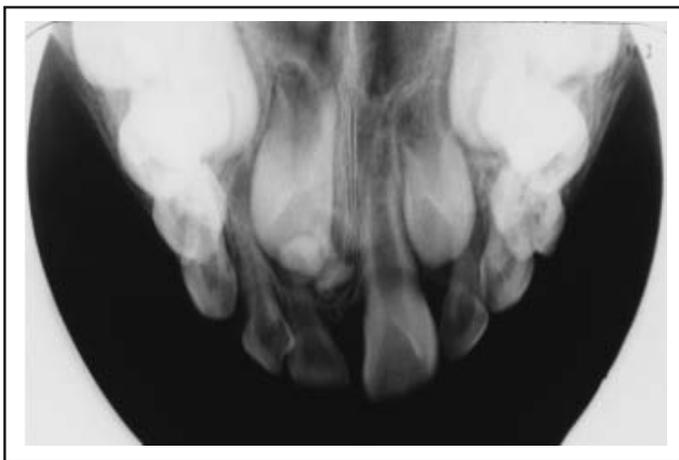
Case 3. An upper anterior occlusal radiograph showing a talon cusp on the primary right lateral incisor, missing permanent successor tooth and the impaction of the permanent right central incisor by an odontome.
